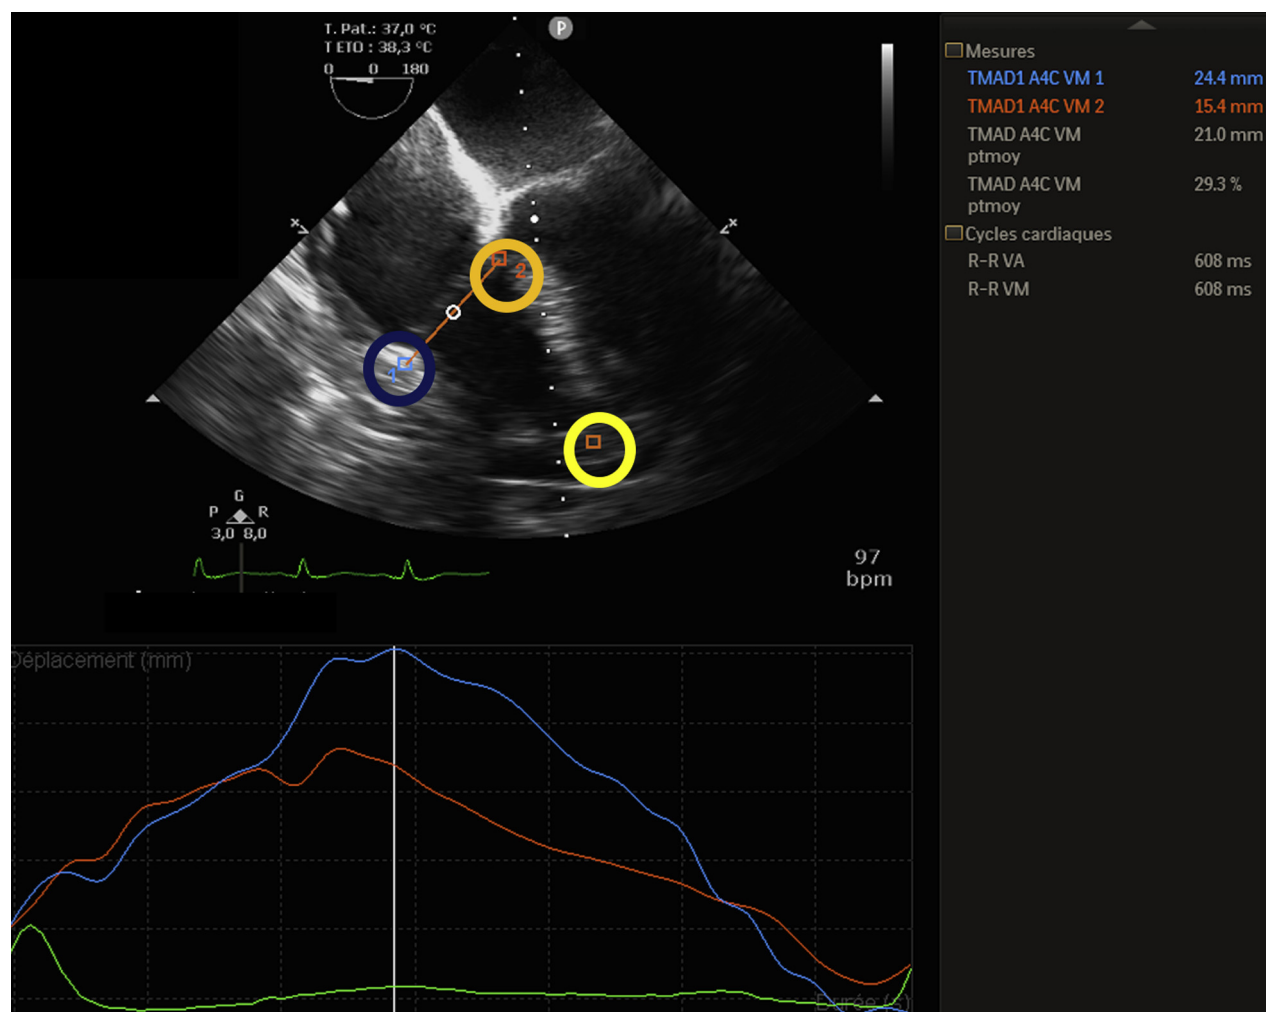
TMAD on transesophageal echocardiography. In a midesophageal four-chamber view, the user-defined anatomic landmarks lateral point (blue circle) and septal point (orange circle) were placed at the bottom of the RV free wall and the bottom of the interventricular septum, and another point was placed at the apex (yellow circle). TMAD_{lat}, TMAD at the at the interventricular septum, and RV longitudinal shortening (%) are displayed.
